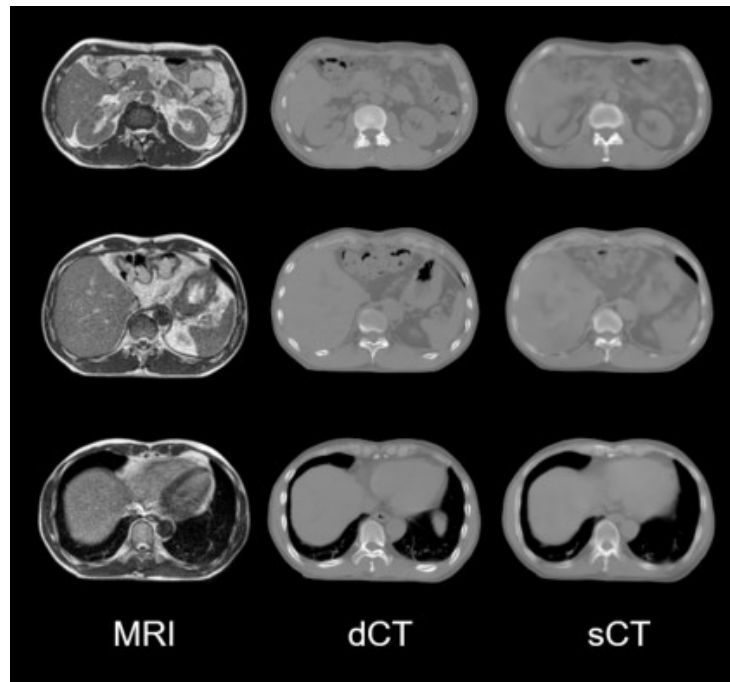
The representative axial slice views of MRI, dCT and sCT for abdomen
